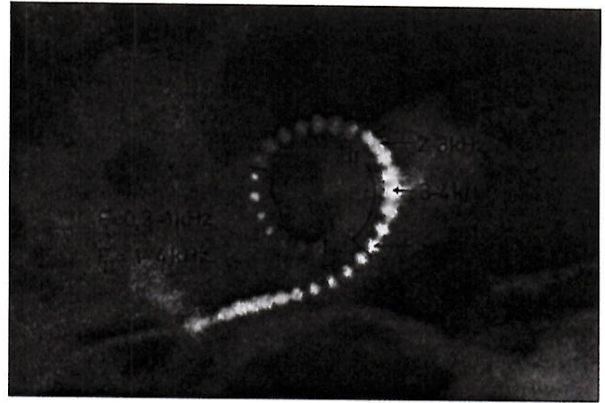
A CT scan showing an electrode array in place, following the curve of the basal coil of the cochlea.
